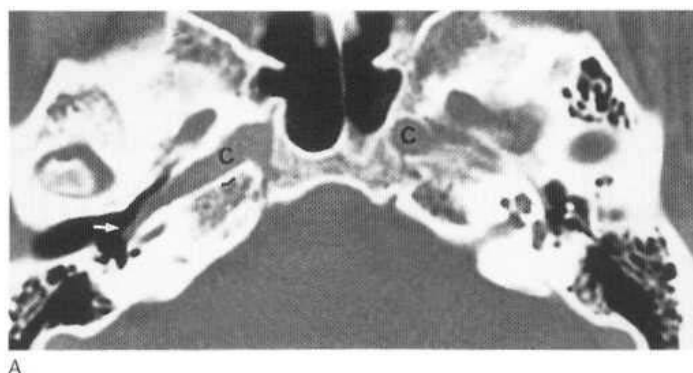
Two different but important vascular anomalies which can be diagnosed on base CT sections, although further imaging in the coronal plane is desirable. (A) Aberrant internal carotid artery (c) in the middle ear (arrow). (B) Large jugular bulb (j), partially dehiscent, in the middle ear cavity. Compare with the normal side in each case.
